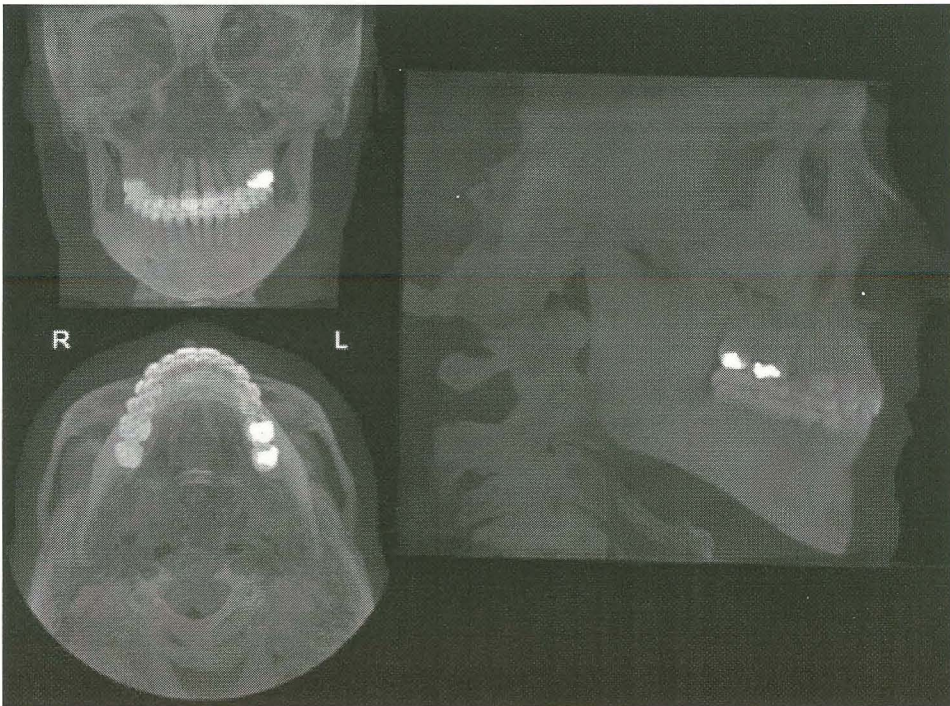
Application of maximum intensity projection algorithms to ray-sum projections show relationships of numerous elements (eg, angulation of tooth roots in alveolar bone) because of their transparent nature. Ray-sum projections provide surface representation of CBCT volumetric data as posteroanterior, submentovertex, and lateral skull images.[65]
